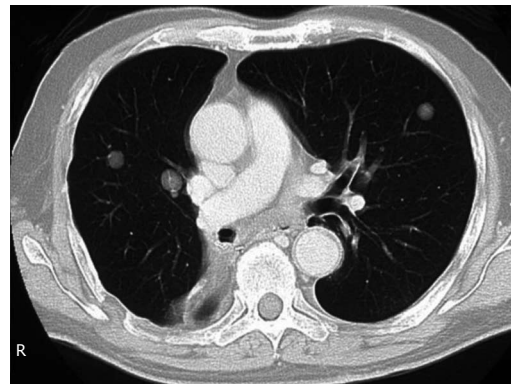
Multiple nodular lesions in the bilateral lung fields observed on chest computed tomography (CT).
